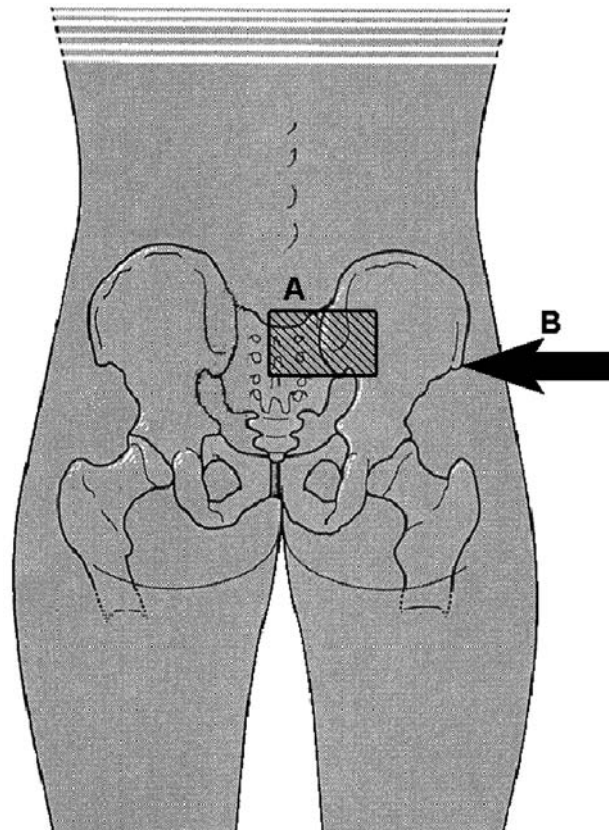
Outline of test position for combined color Doppler imaging (CDI) and electromyographic (EMG) measurements. A Location of the CDI probe over both sacrum and ilium on one side of the pelvis. B Positioning of the oscillator plate against the anterior superior iliac spine
